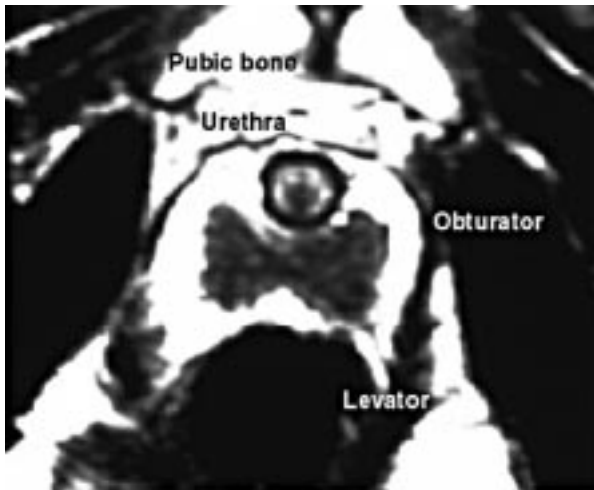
MRI by vaginal coil Zonal anatomy of the urethra
